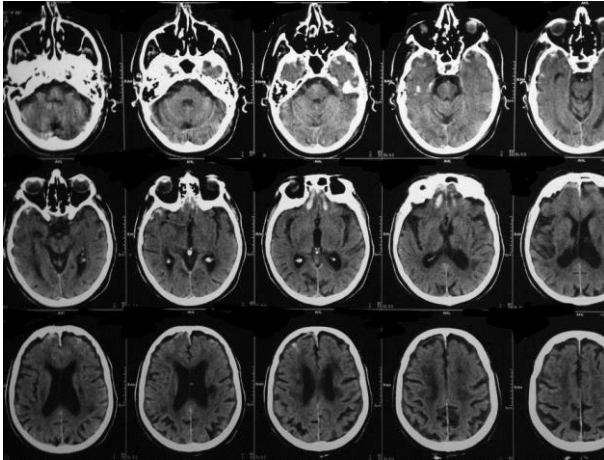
CT scan head on admission
